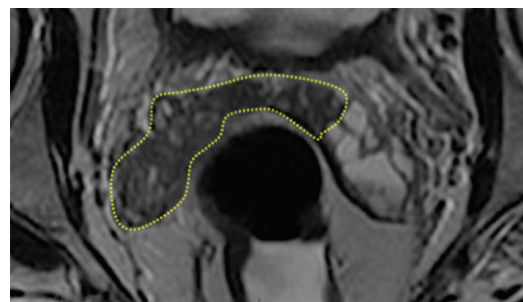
Axial T2-weighted MR image in a 74-year-old man shows abnormally low signal intensity in the right seminal vesicle and medial segment of the left seminal vesicle (dotted line), which is suggestive of infarction. (Reprinted, with permission, from reference 64.)
